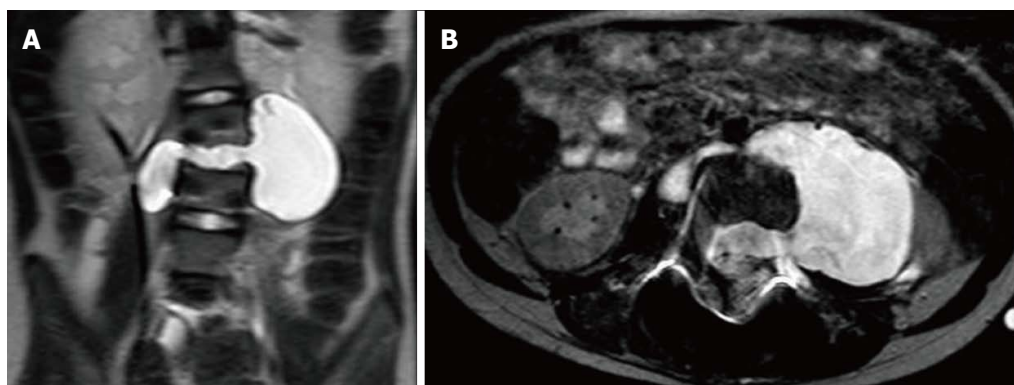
T2-weighted coronal (A) and axial (B) magnetic resonance imaging one month after the trauma showing LCS leakage in the abdominal cavity.
